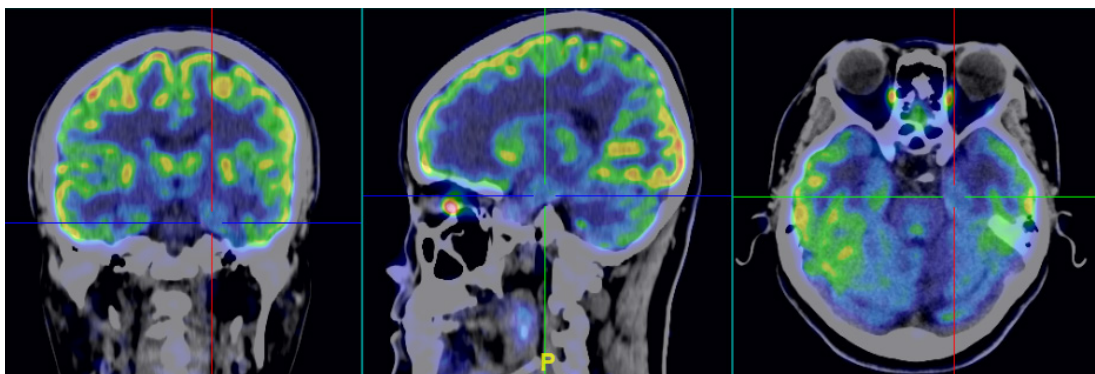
Interictal FDG-PET scan in case 12. The patient shows left AE on MRI and FDG-PET demonstrates ipsilateral hypometabolism in the enlarged amygdala and mesial temporal lobe.
